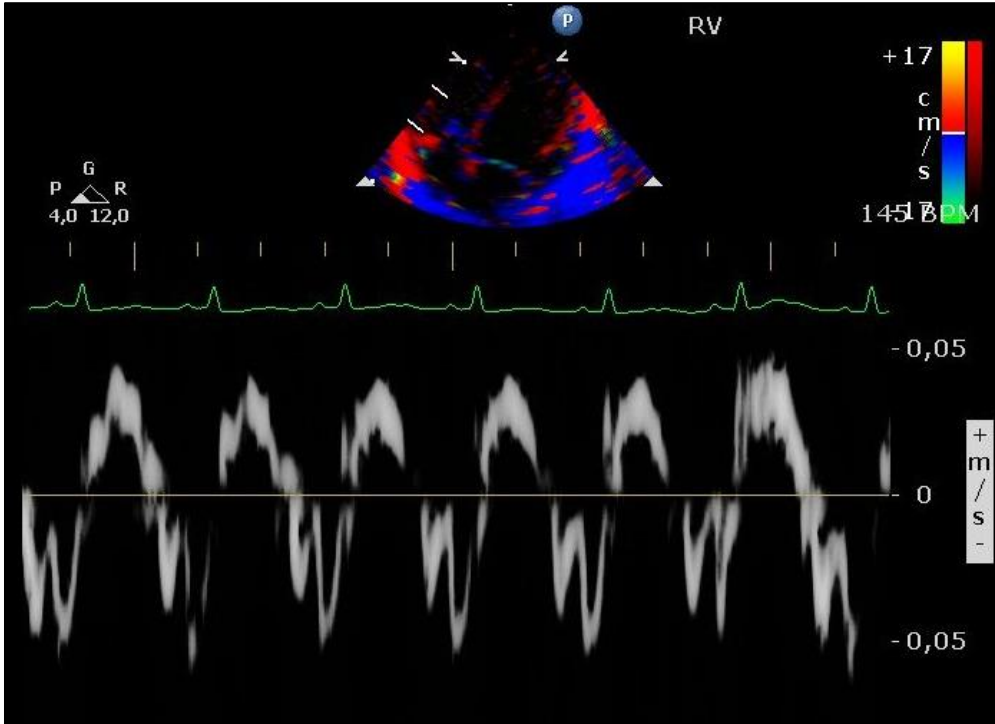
Functional echocardiography depicting tissue Doppler imaging of the right ventricle.
